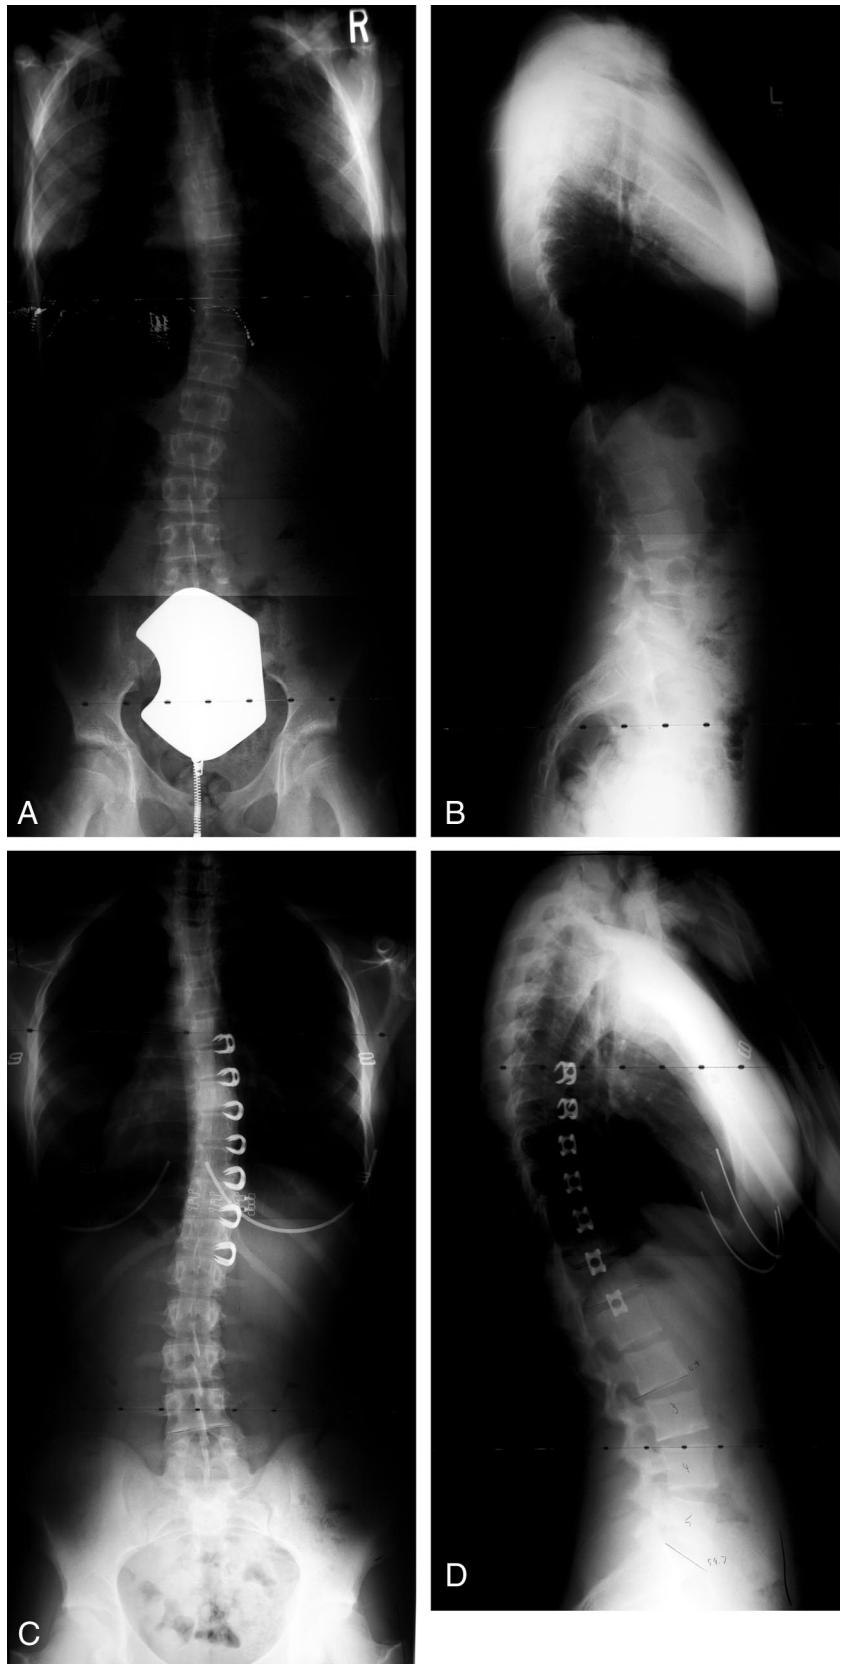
A–D, PA (A) and lateral (B) erect radiographs of a 12-year-old girl demonstrate a 31° right thoracic curve and 15° thoracic kyphosis. The patient underwent a thoracoscopic VBS from T5–T12. Her first erect radiographs demonstrate curve correction to 19°. (C, D) Latest follow-up shown here at 4.1 years postop demonstrates maintenance of curve correction at 22° and a thoracic kyphosis of 28°.
